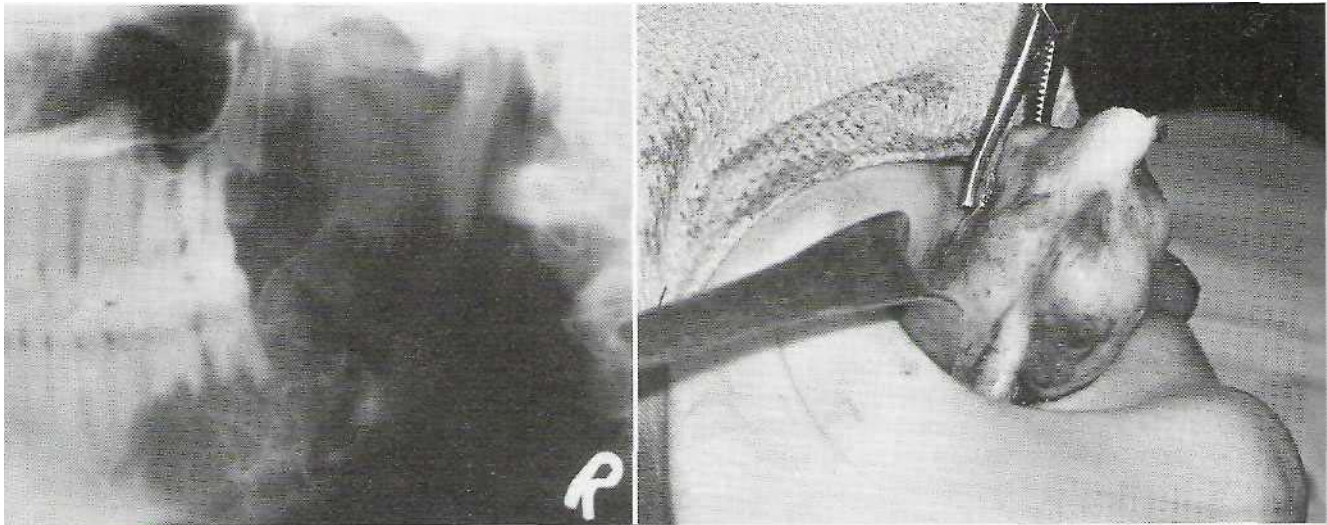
Partial mandibular resection of myxoma. A, Radiographic appearance on initial presentation. B, Photograph of intraoral resection of tumor (surgical resection similar to that shown in Fig. 22-8, 6). (B from Ellis E, Fonseca RJ: Therapy of cysts and odontogenic tumors. In Thawley SE et al, editors: *Comprehensive management of head and neck tumors*, ed 2, Philadelphia, 1999, WB Saunders.)
